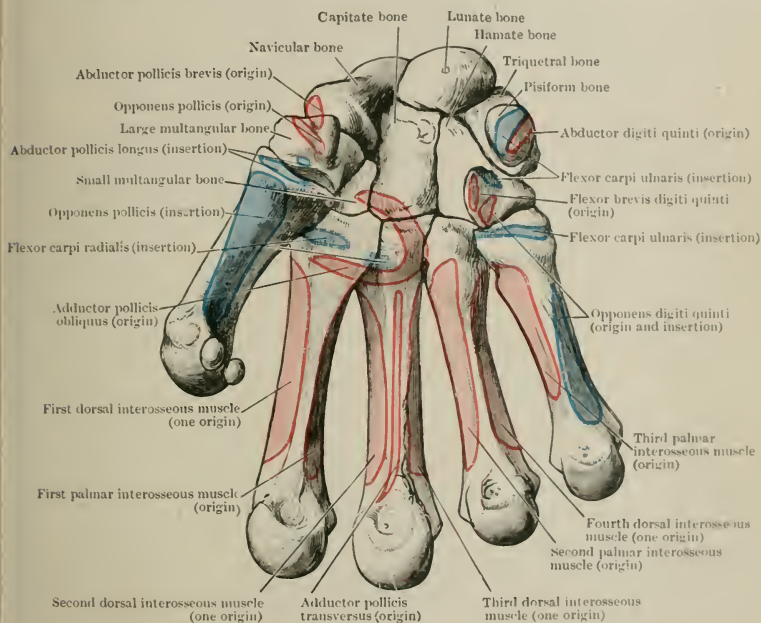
THE PALMAR ASPECT OF THE CARPUS AND METACARPUS, WITH MUSCLE ATTACHMENTS.
